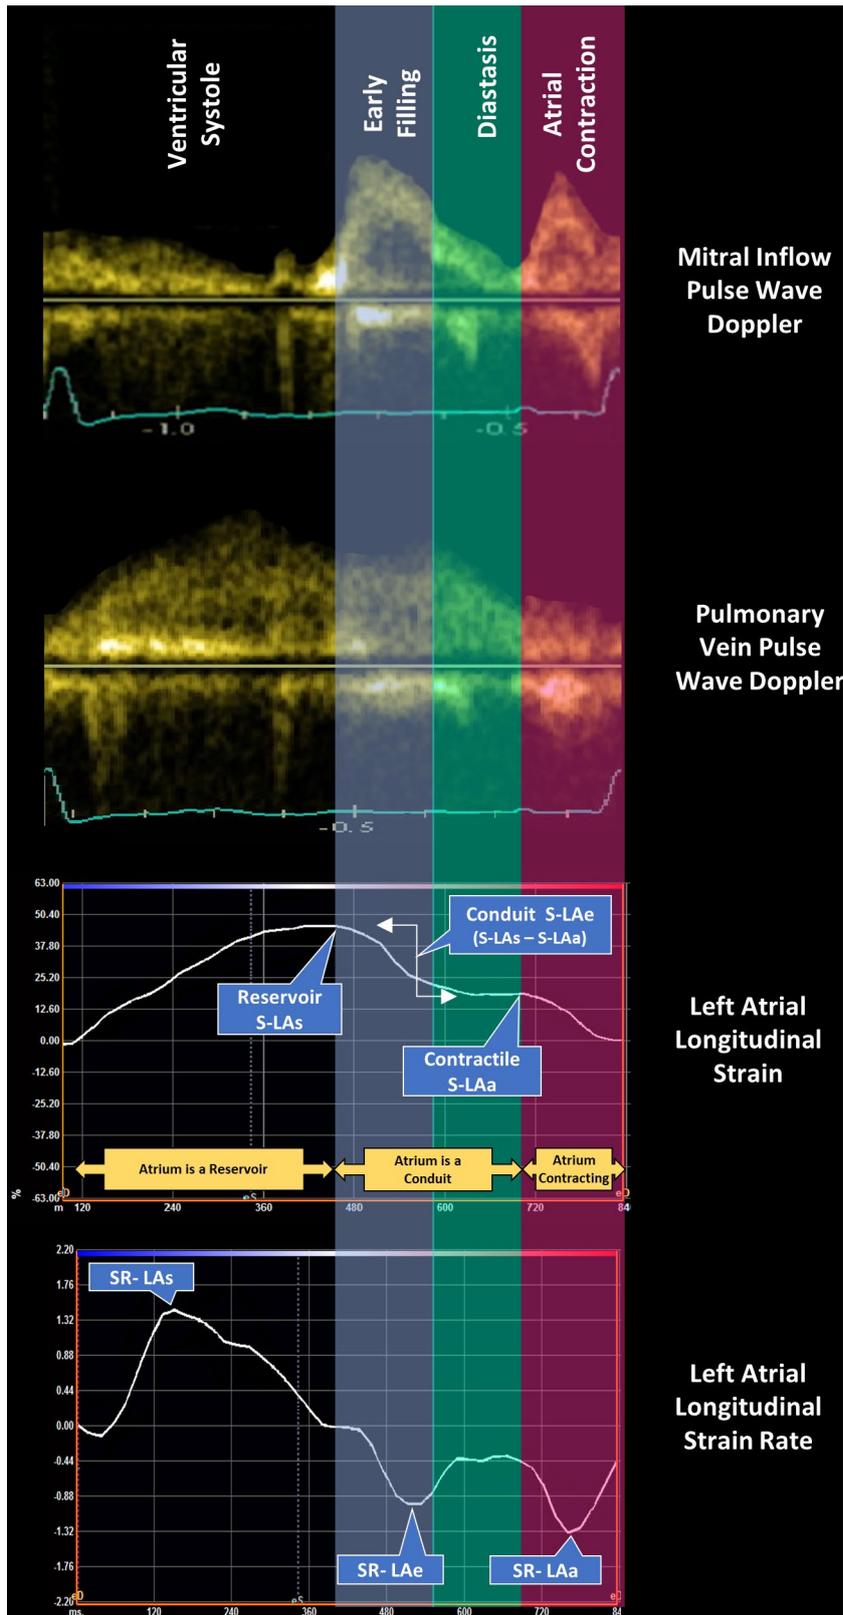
LA strain and SR curves summarising measurement of the three LA functions with comparison to the traditional Doppler parameters including mitral inflow and pulmonary venous pulse wave Doppler traces (From Rausch et al) [24].
